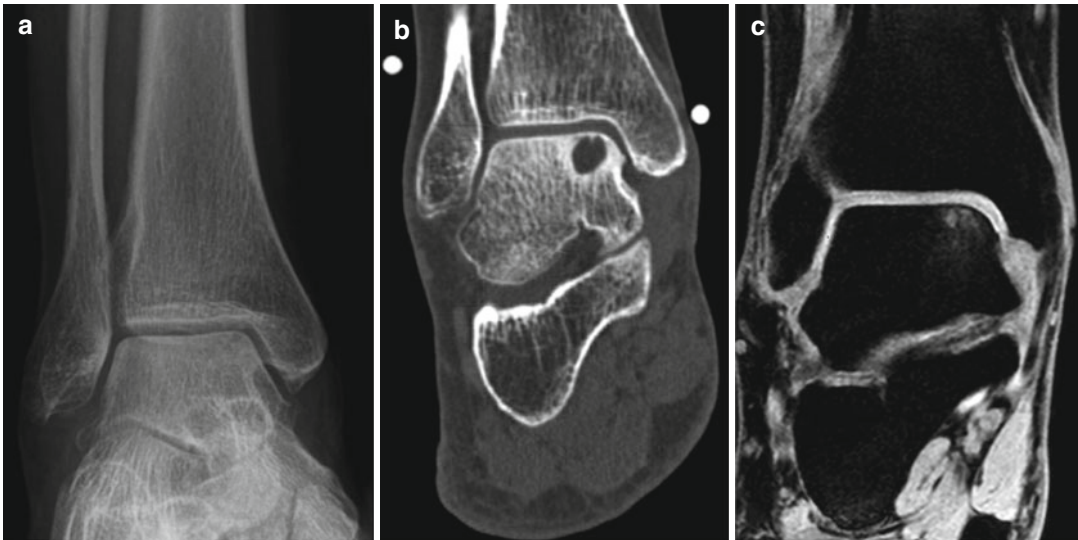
(a) X-ray. (b) CT scan. (c) MRI of a medially located OCD. On the X-ray the OCD is not clearly visible and will be missed by routine screening. On the CT scan, a subchondral cyst is visible, secondary to the OCD. The
